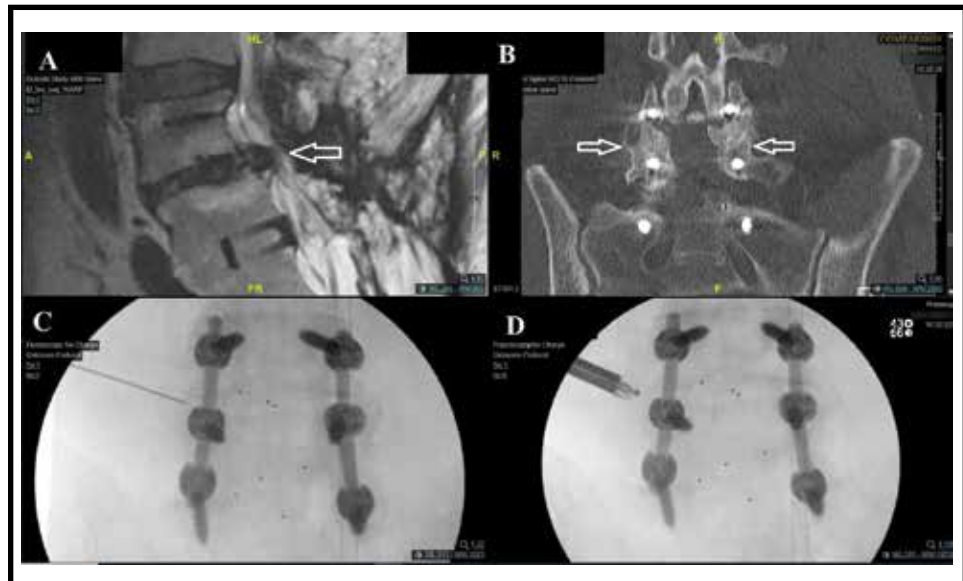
Transforaminal decompression of a left L4-5-disc herniation and foraminal narrowing after an L4-S1 fusion. A. Sagittal T2-weighted MR image demonstrating the left L4-5-disc herniation at L4-5. B. Coronal CT image demonstrates the instrumented L4-S1 fusion with large posterolateral fusion mass (open arrows). C. AP fluoroscopic image demonstrates the spinal needle targeting the left L4-5 foramen but being blocked by the posterolateral fusion mass. D. AP fluoroscopic image demonstrates the endoscopic diamond drill used to penetrate the fusion mass to allow access to the foramen.
